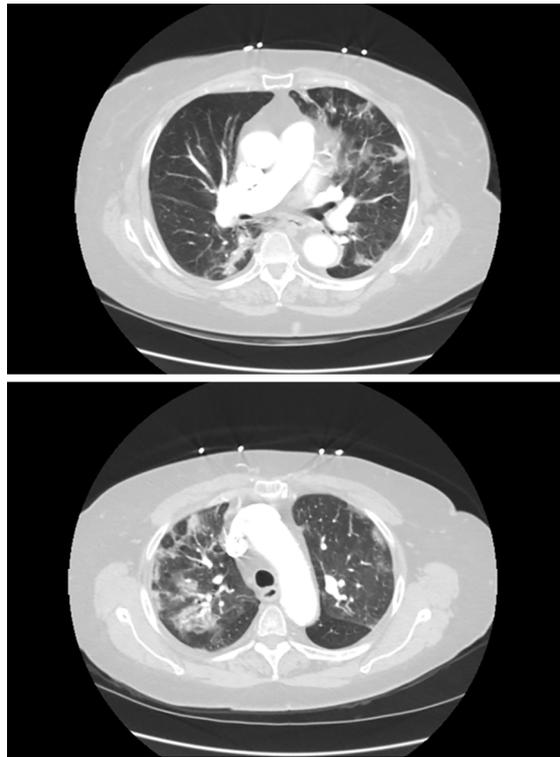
Computed tomography chest showing bilateral ground glass opacities.
